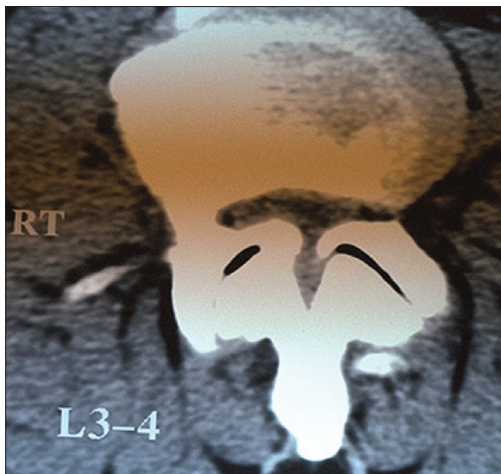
The axial non-contrast lumbar CT scan demonstrates marked congenital stenosis accompanied by superior facet hypertrophy. Note that air (hypodense) within the facet joints is indicative of instability. With such severe spinal stenosis, epidural steroid injections would likely fail or result in dural fistulas as there is essentially no epidural compartment. Similarly, if this patient had a synovial cyst, there would have been virtually no space available for "cyst aspiration"
